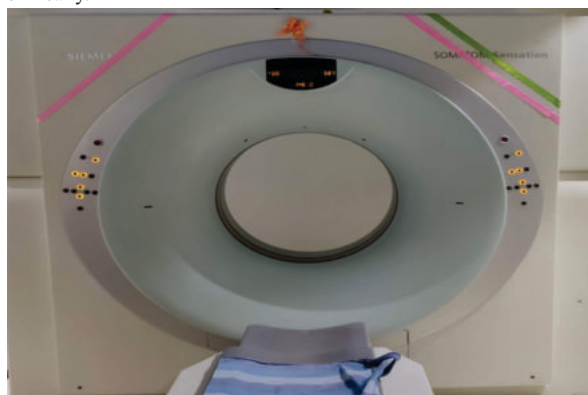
Image of SIEMENS SOMATOM 64 Slice CT machine used in this study.
